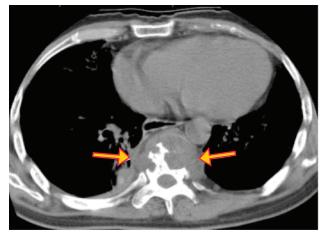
Pott disease. Non-contrast CT shows vertebral body osteolytic lesions surrounded by a paraspinal abscess (arrows) and small right-side pleural effusion.
